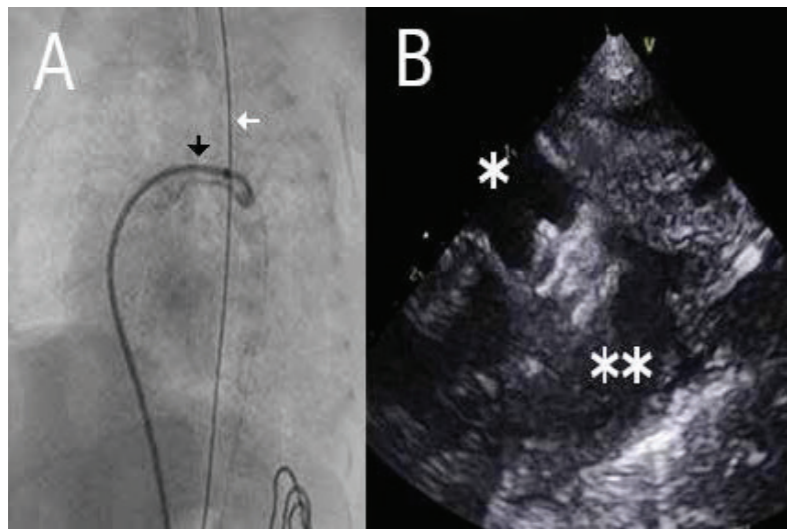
(A) Aortography in LAO projection. PDA is delineated (black arrow) with a hand injection of 1 ml of contrast. Nasogastric tube (white arrow) was also helpful during deployment of the device. (B) Echocardiography shows the Piccolo device interposed between the Pulmonary trunk (*) and the descending Aorta ()
